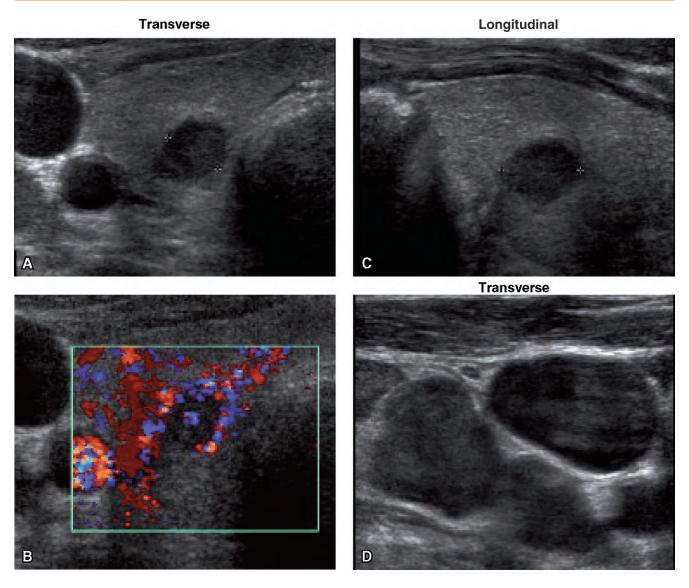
Ultrasound of metastasis in the right lobe (pulmonary carcinoma). A, Transverse diameter: 7 mm. B, Color Doppler, transverse. C, Longitudinal, sagittal diameter: 10 mm. D, Neck, Transverse, metastases.
